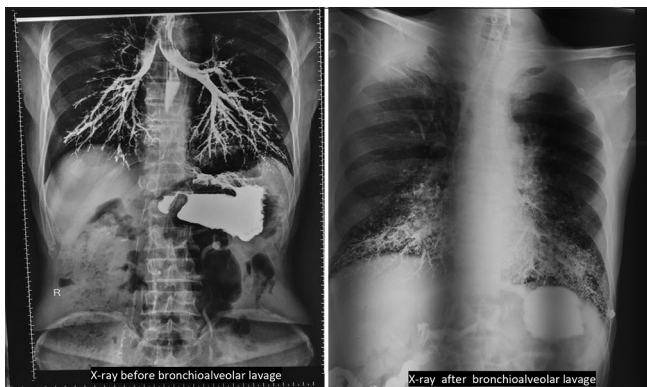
X-ray before/after bronchoalveolar lavage
